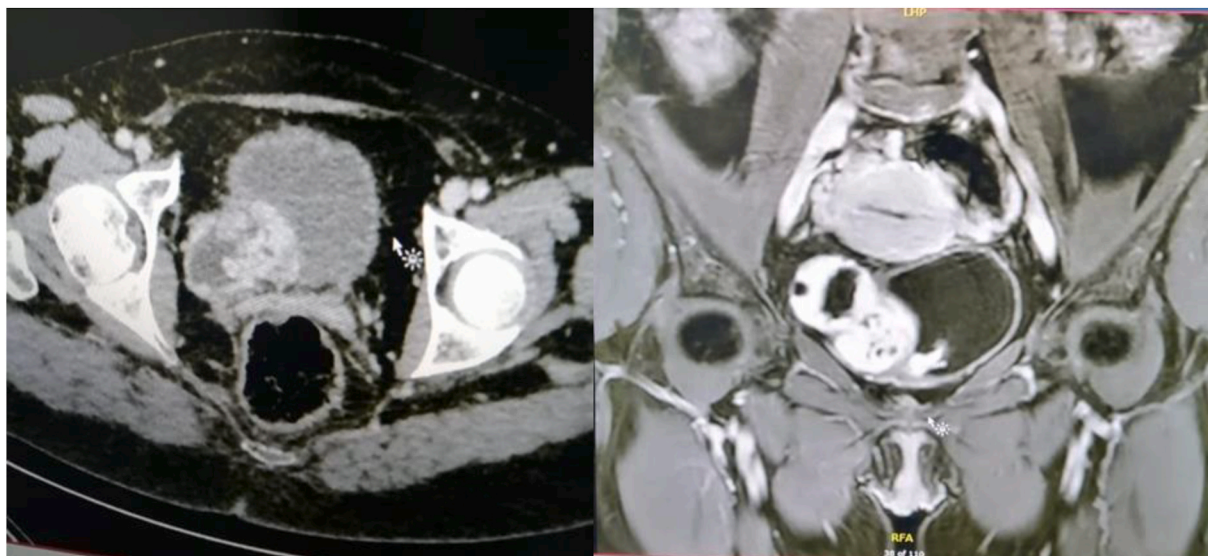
Abdominal CT and pelvic MRI of the patient.
